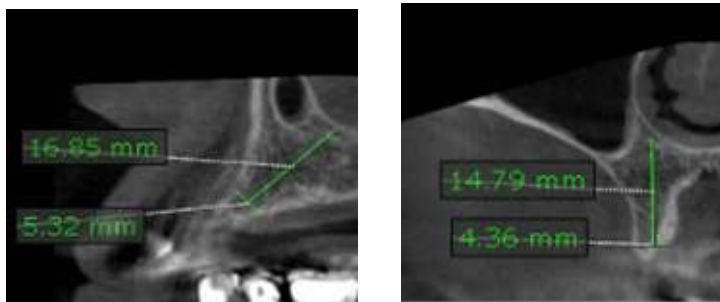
Measurement of bone volume on (A) Sagittal section of CBCT (B) Coronal section of CBCT
